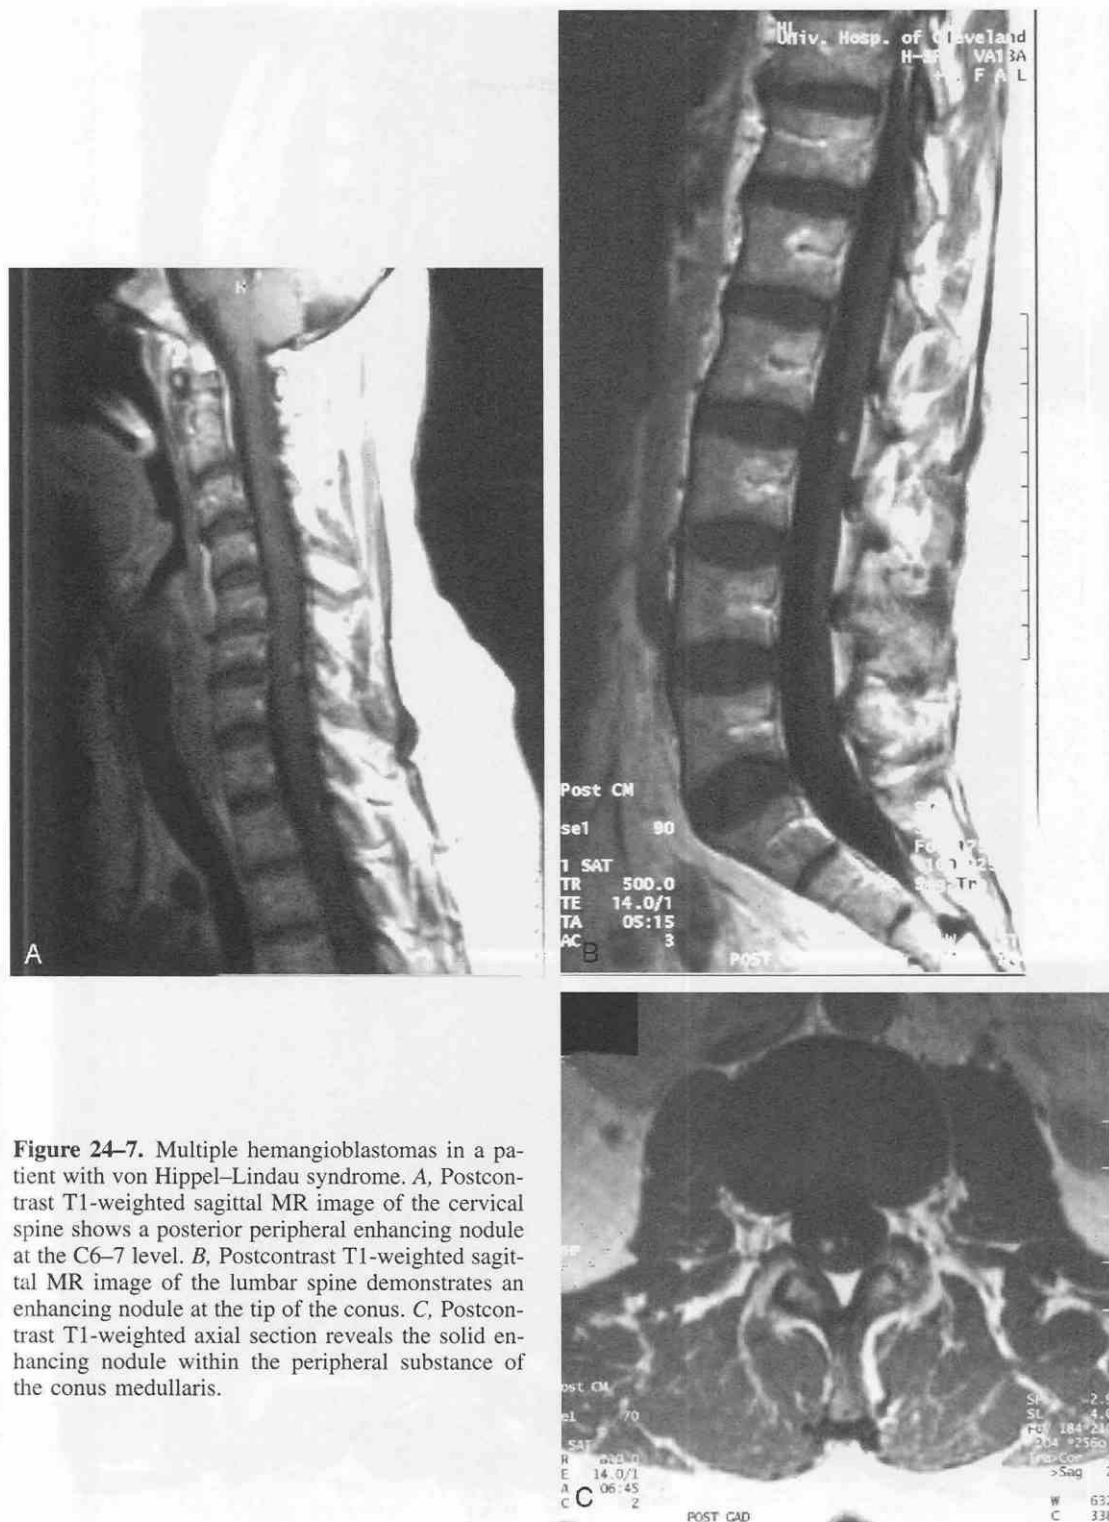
Multiple hemangioblastomas in a patient with von Hippel-Lindau syndrome. *A*, Postcontrast T1-weighted sagittal MR image of the cervical spine shows a posterior peripheral enhancing nodule at the C6-7 level. *B*, Postcontrast T1-weighted sagittal MR image of the lumbar spine demonstrates an enhancing nodule at the tip of the conus. *C*, Postcontrast T1-weighted axial section reveals the solid enhancing nodule within the peripheral substance of the conus medullaris.
